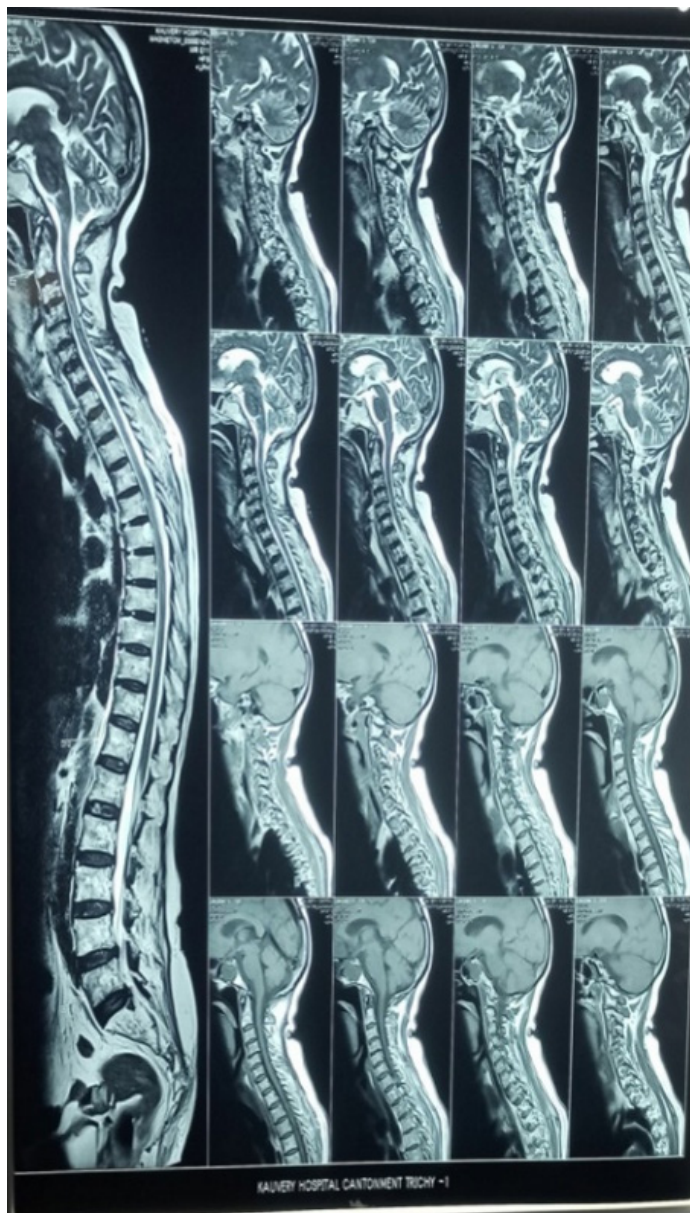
MRI Cervical Spine. We're looking at sagittal and axial MRI images of the cervical and upper thoracic spine, captured through various sequences like T1, T2, and STIR. These images help us assess the spinal cord and vertebral column, checking for structural integrity and looking out for issues like demyelination, inflammation, compression, or other pathologies. The images are taken from different levels and angles to ensure a thorough evaluation.
